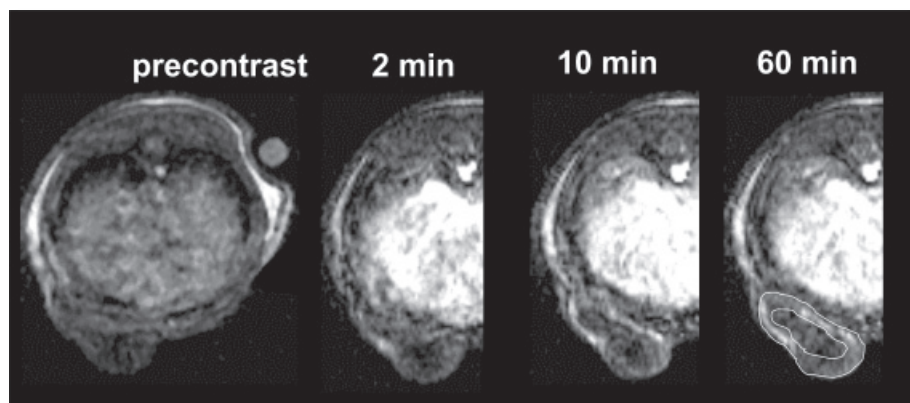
T1-weighted SPGR image of a mammary adenocarcinoma before and 2, 10 and 60 minutes after administration of albumin-(Gd-DTPA)₃₀ (0.03 mmol/kg). A ROI was placed in the periphery of tumor.
